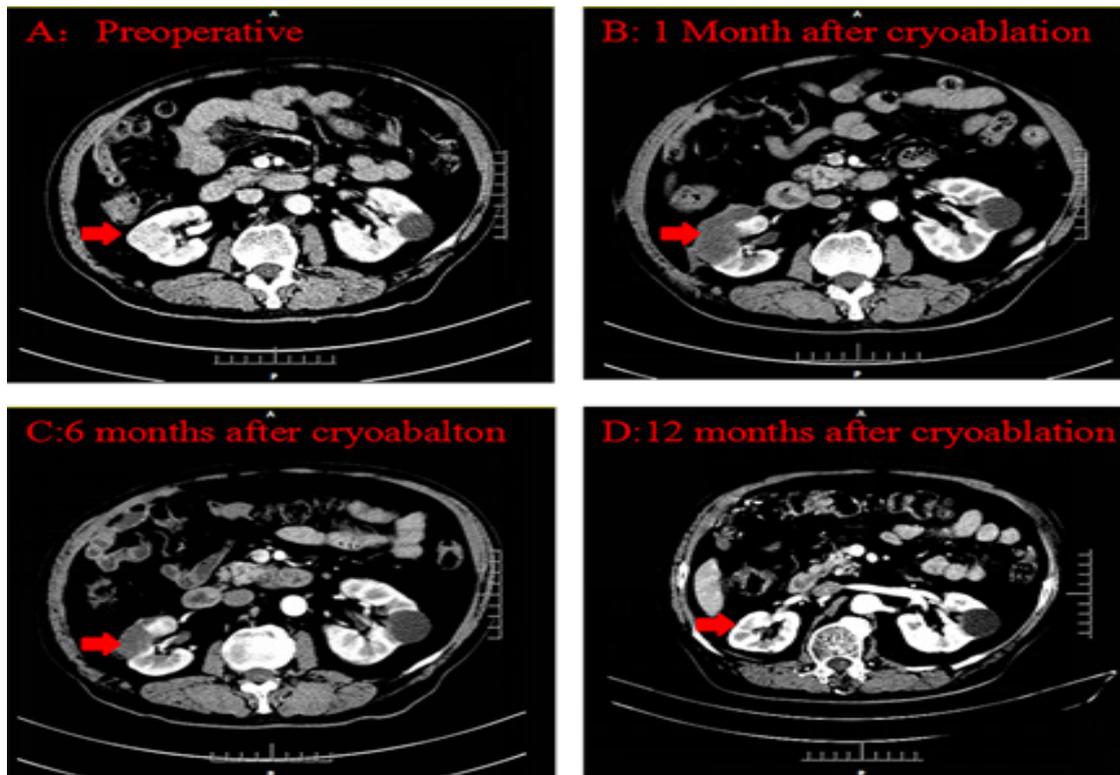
Typical images of the effect of cryoablation therapy in the same patient: A: Significant uneven enhancement was seen in the center of the right renal before surgery. B: Postoperative renal CT examination showed no obvious enhancement in the frozen region after one month, and large necrotic tumor tissue was seen. C: There was no obvious enhancement in the operational area after six months, but necrotic tumor tissue decreased. D: 12 months after surgery, there was almost no necrotic tissue in the treated area, and no obvious abnormal enhancement was observed, indicating the efficacy of tumor therapy. Tumor area and frozen area were marked with red arrow.
